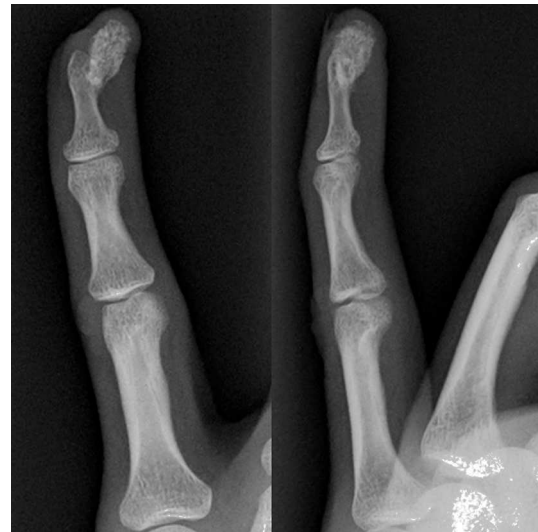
Anteroposterior (A) and lateral (B) X-rays of the fifth finger of the left hand showing an ossified nodular lesion attached to the periosteum of the distal phalanx without cortical erosion.
